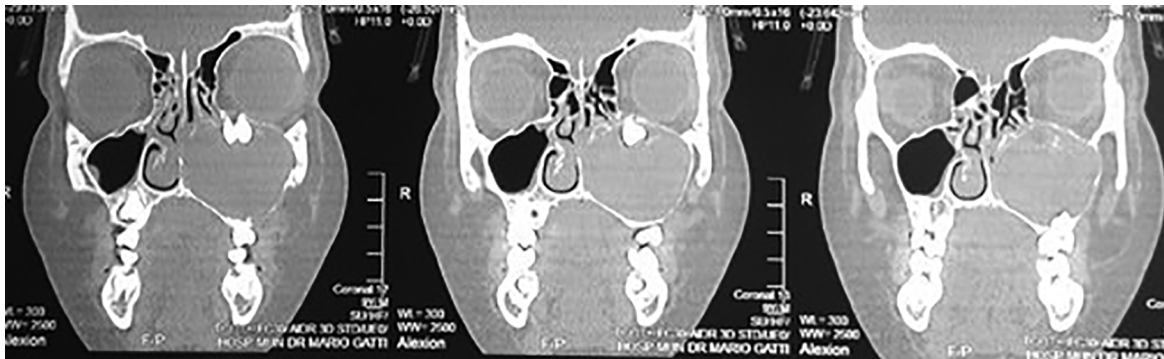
Computed tomography image in coronal section showing the lesion dimension, bulging of the lateral wall of the ipsilateral nasal cavity. Dental element impacted in the orbital region.
